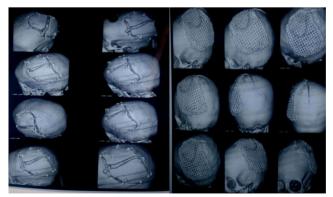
Follow up CT showing fracture of CT brain showing titanium mesh replacing Bone cement
